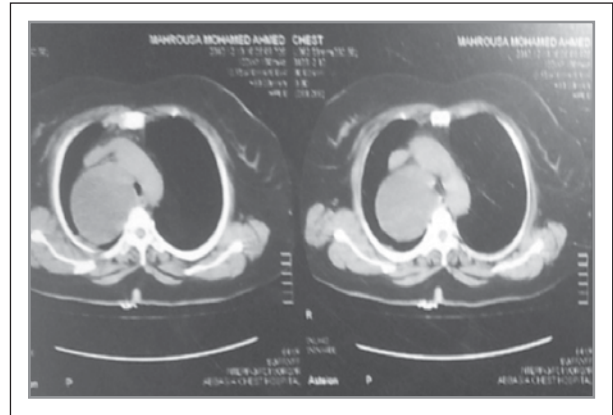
Computed tomographic scan of the chest showed a round mass, 70x60 mm in size, at the right side of the middle mediastinum
